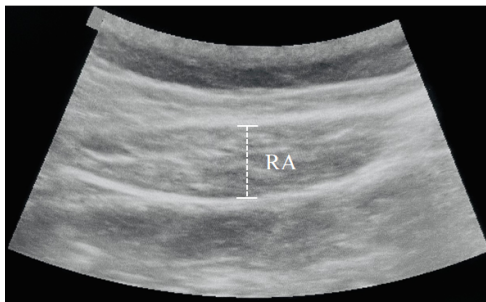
Ultrasonography images of rectus abdominis
